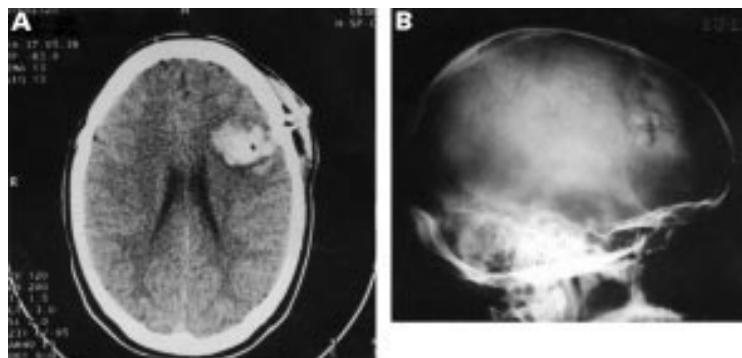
(A) Computed tomography showing left frontal intracerebral haematoma and skull vault fracture with (B) corresponding plain skull radiograph showing a depressed skull fracture.
